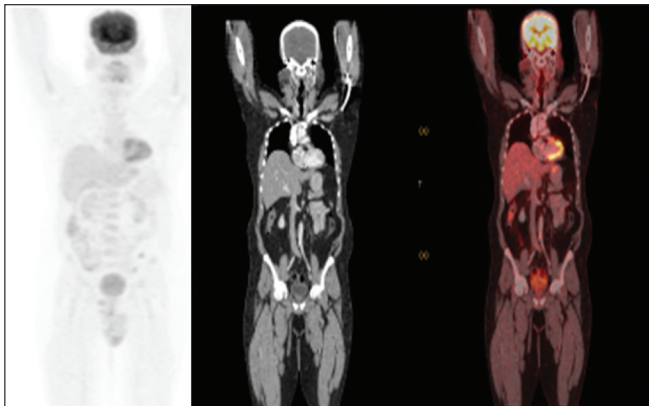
Positron emission tomography/computed tomography image showing metabolically active hypo dense area encircling the superior vena cava right atrial junction
